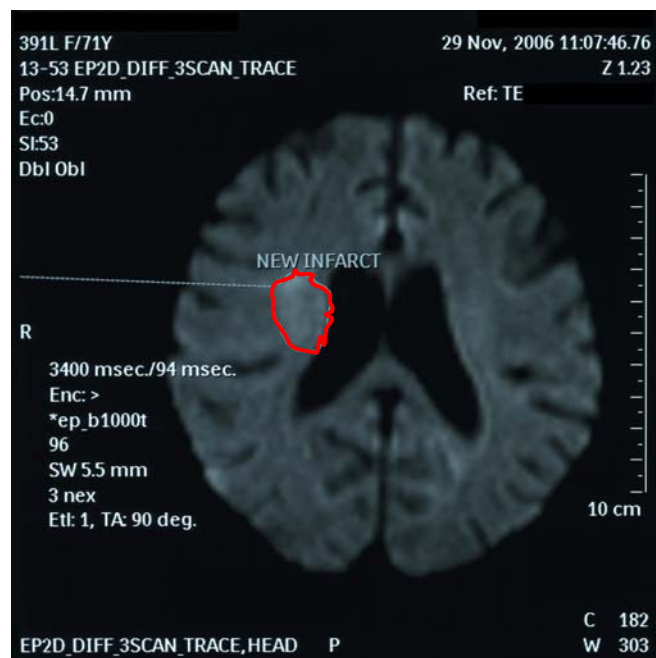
New infarcts appear as white densities on an MRI
